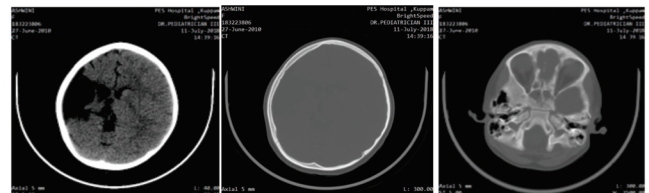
Cranial CT Showing right cerebral atrophy, calvarial thickening and hyperpneumatization of bilateral mastoid air cells.
